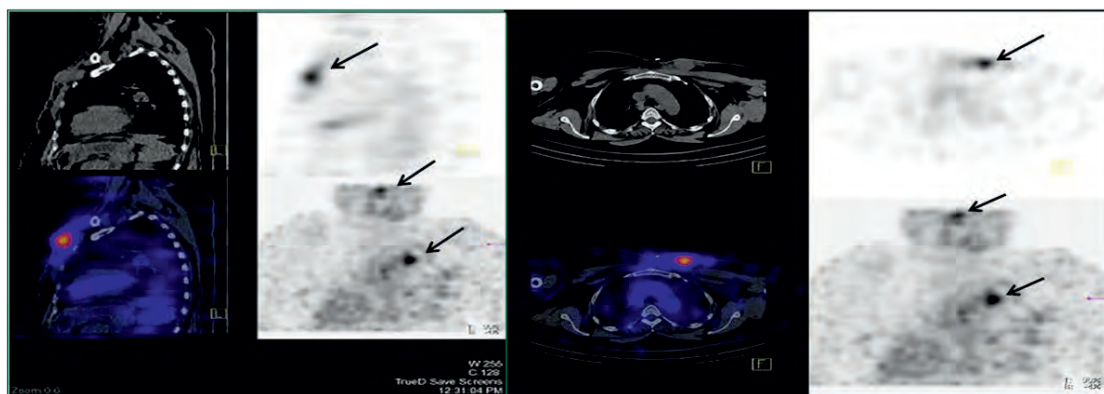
SPECT-CT scans of a patient, suffering from Non-Hodgkin's Lymphoma, obtained using in-house formulated ^{177}Lu -Rituximab
